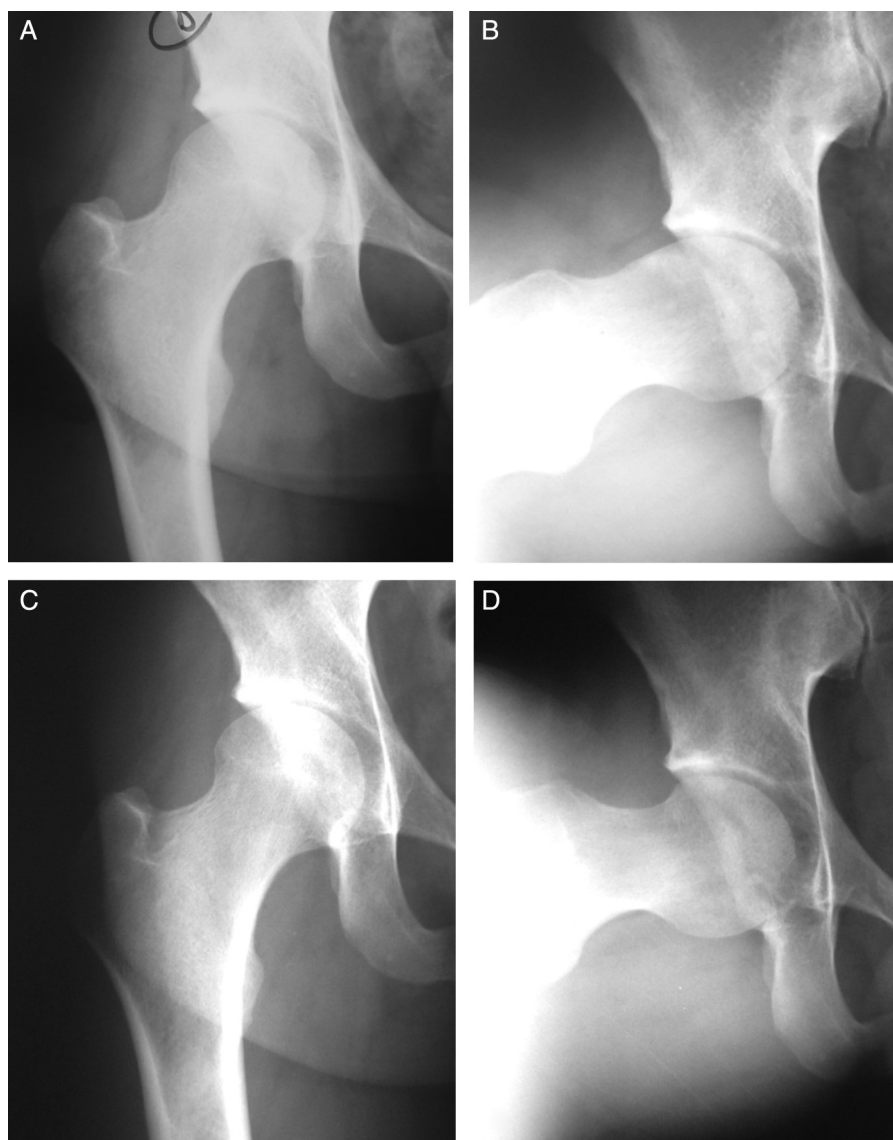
Male patient aged 32 years. Preoperative internal rotation of 5°. (A, B) Preoperative radiographs showing FAI of cam type, θ_{CE} : 27° and θ_{α} : 68°. (C, D) Radiographs produced 3 years and 2 months after the operation, in which femoral osteochondroplasty had been performed in association with labral debridement. The patient evolved well, to internal rotation of 18°, with normalization of θ_{α} .
